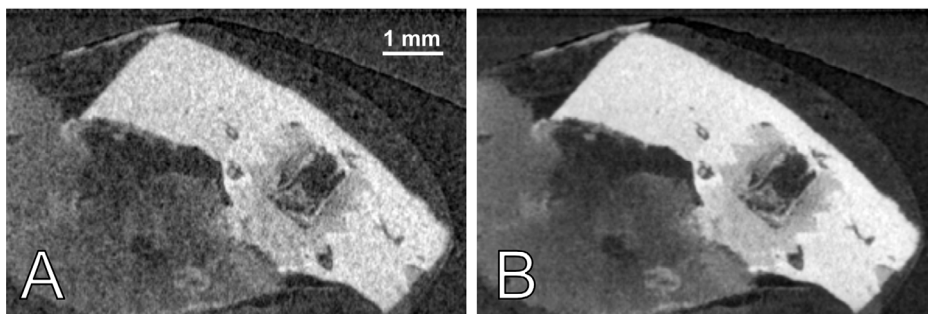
Example of smoothing filter applied to neutron μ CT scans of biodegradable implants in bone. A non-local means filtering algorithm (Buades et al., 2005), implemented in Amira, was used to reduce the salt-and-pepper noise, caused by the low neutron flux at high-resolution imaging experiments. Compared to the non-filtered image (A), the filtered image (B) shows better signal-to-noise ratio, and improved visibility of the features. Data acquired as part of Paper V.
